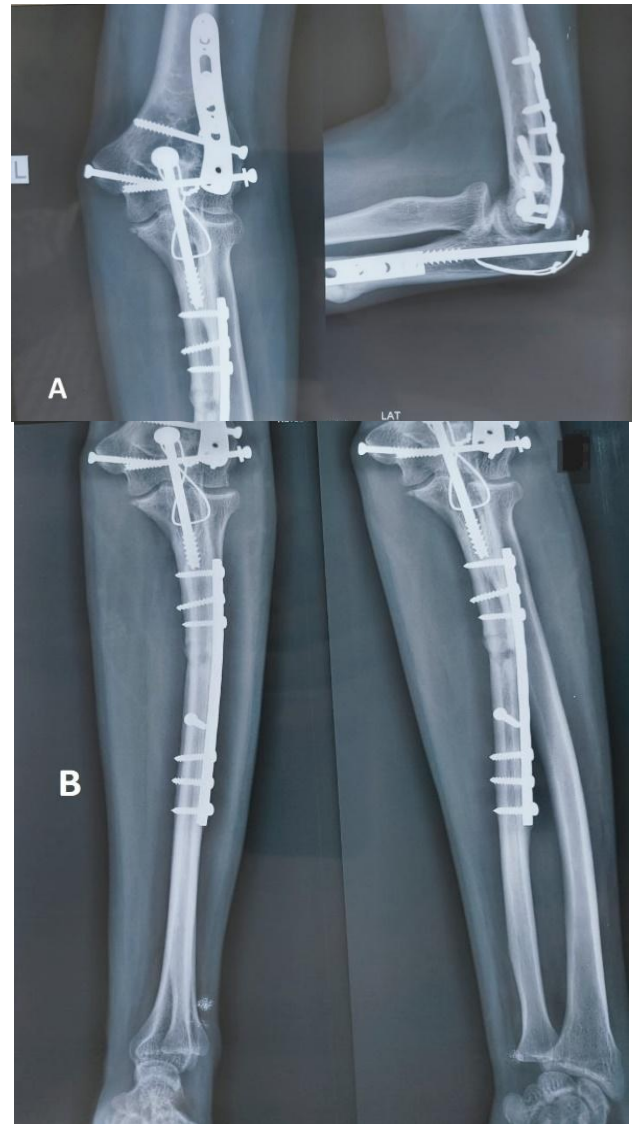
(A and B): Radiograph of the left elbow and the forearm at the end of 12-months follow-up. Image shows maintenance of the concentric reduction of all 3 articulations of the elbow joint with united distal humerus and ulna fracture.
